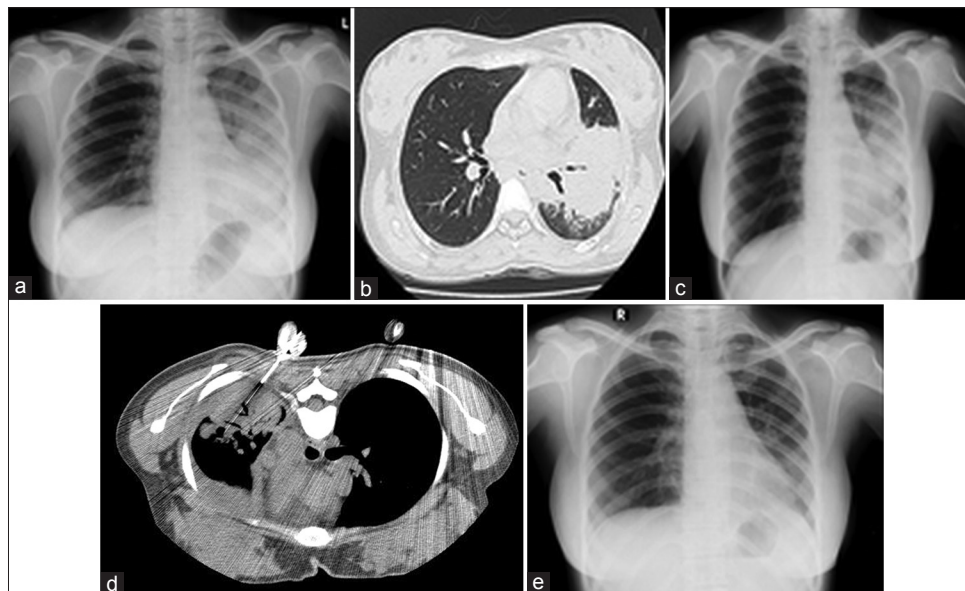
(a) Chest radiograph (PA view) showing left lower zone haziness suggestive of consolidation with effusion; (b) Contrast-enhanced CT thorax image showing consolidation in the left lingular and lower lobe and mild pleural effusion; (c) Chest x-ray obtained three weeks after the antibiotic course shows minimal resolution of consolidation in the left lung; (d) A repeat CT thorax performed three weeks after antibiotic therapy shows persisting consolidation in the lingular lobe left lung with increase in pleural effusion. Note the biopsy needle *in situ*; (e) Chest x-ray obtained one month after addition of antitubercular therapy shows significant radiological resolution of the consolidation
